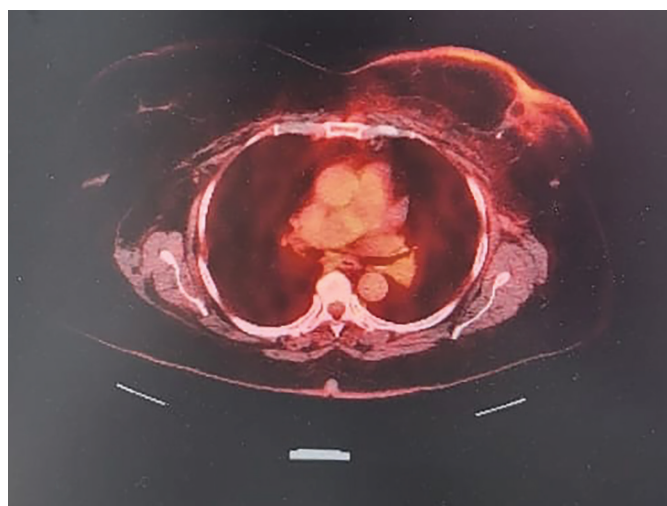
Positron emission tomography-computed tomography of left breast showing fluorodeoxyglucose-avid skin enhancement of the medial aspect of the left breast
